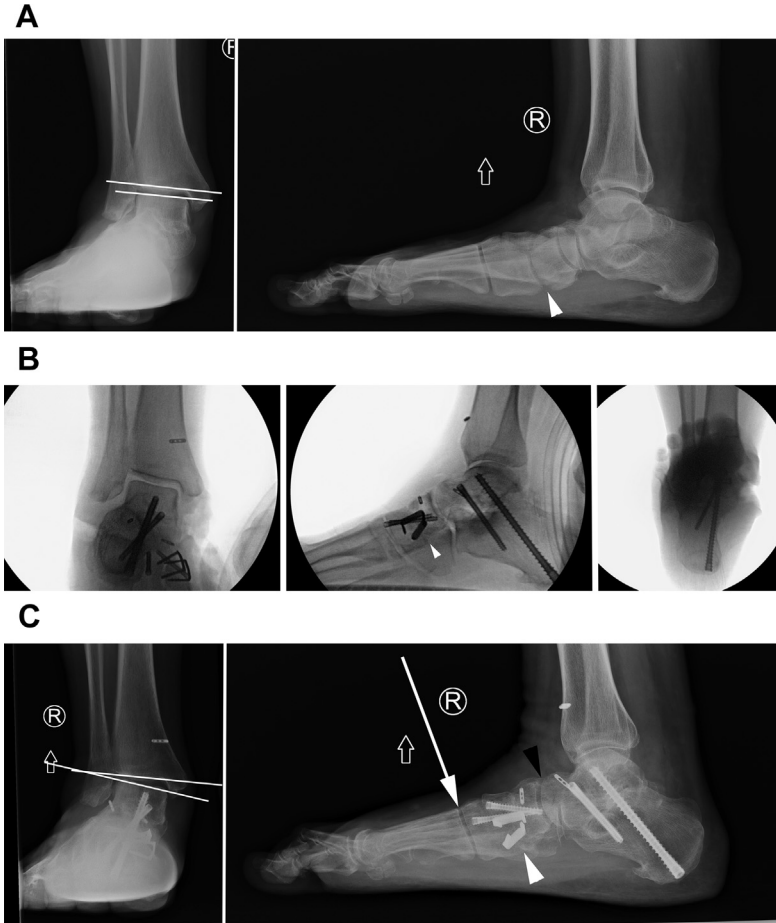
Preoperative AP and lateral radiographs (A) showing a flatfoot deformity with clear collapse at the NC joint with a neutral tibiotalar joint. Intraoperative fluoroscopy (B) was performed secondary to the instability of the subtalar joint and obesity with associated NC fusion and allograft spring ligament reconstruction. Appropriate alignment was thought to be achieved with correction of the sagittal plane deformity and restoration of a neutral axis of the hindfoot. Medial column failure occurred in this case through the deltoid ligament with subsequent ankle valgus (C). The remaining medial column, including the first TMT joint (white arrow), NC arthrodesis (white arrowhead), and TN joint (black arrowhead) maintained their positions, which may explain why the collapse occurred through the deltoid ligament.
